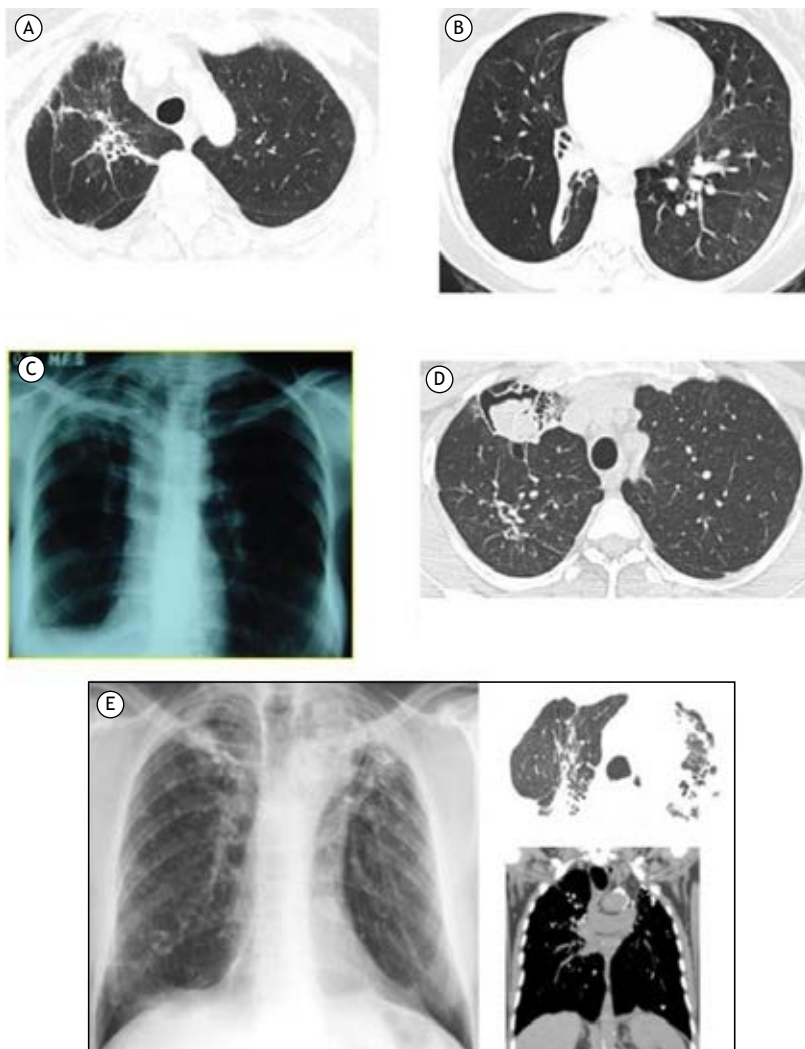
Radiological patterns of post-tuberculosis lung disease. In A, a chest CT scan showing irregular dense opacity with bronchiectasis from the hilum to the right lung apex associated with apical pleural thickening, elevation of the hilum, and volumetric reduction on this side. In B, a chest CT scan showing consolidative opacity with a fibroatelectatic appearance in the right lower lobe, predominantly affecting the anterior, lateral, and posterior basal segments, determining its volumetric reduction and highlighting the associated bronchiectasis in the anterior basal segment. Cylindrical bronchiolectasis in the upper segment of the right lower lobe. In C, a chest X-ray showing fibrotic opacity in the right upper lobe with pleural thickening and volumetric reduction of the right lung, leading to elevation of the right phrenic dome. In D, a chest CT scan showing a residual excavated lesion in the anterior segment of the right upper lobe filled with mobile contents upon change of decubitus, corroborating repercussions of superimposed saprophytic fungal infectious involvement. In E, imaging scans showing confluent laminar atelectasis, volumetric loss, and architectural distortion in the upper lobes, with intervening calcifications, favoring chronic/residual changes.
